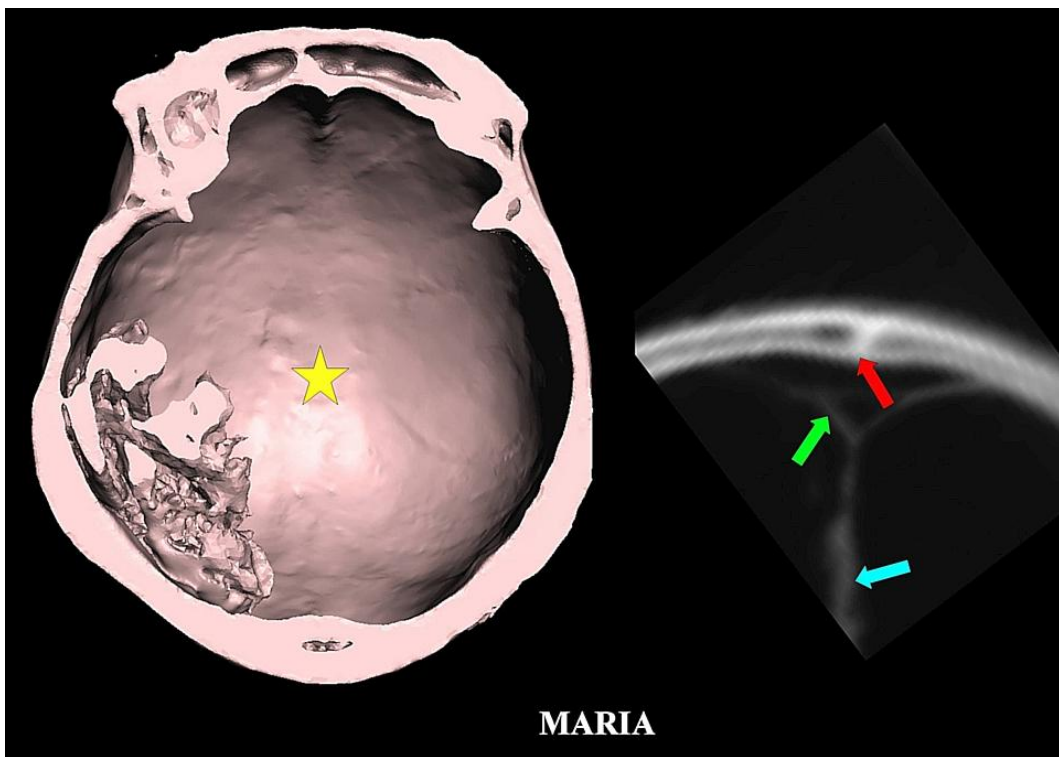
3D CT inferior view of cut section of skull vault (*left*) showing smooth inner surface with lack of identifiable sagittal suture (location of *yellow star*) and coronal suture. Skull bone appeared thick posteriorly. Brain remnant was noted on right side. 2D coronal CT scan (*right*) showing the fused suture (*red arrow*) within bone with continuous inner and outer tables. Superior sagittal sinus (*green arrow*) and falx cerebri (*blue arrow*) were also noted.
